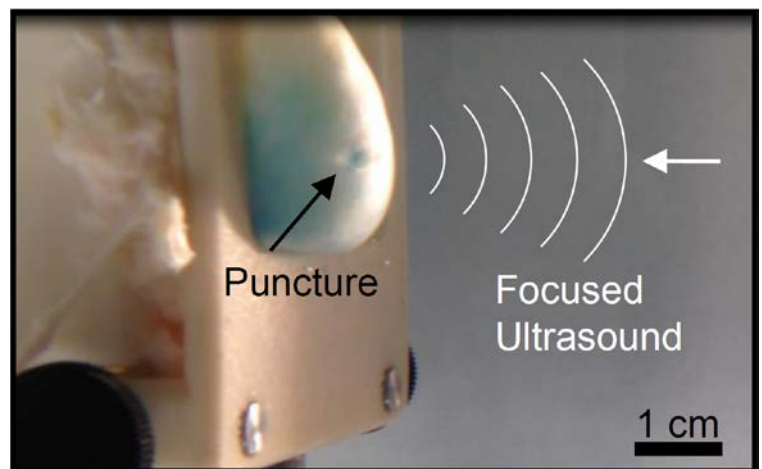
Puncture created in a bladder bleb after 180 seconds exposure of high-intensity ultrasound (indicated by white lines) focused onto the bleb wall.
